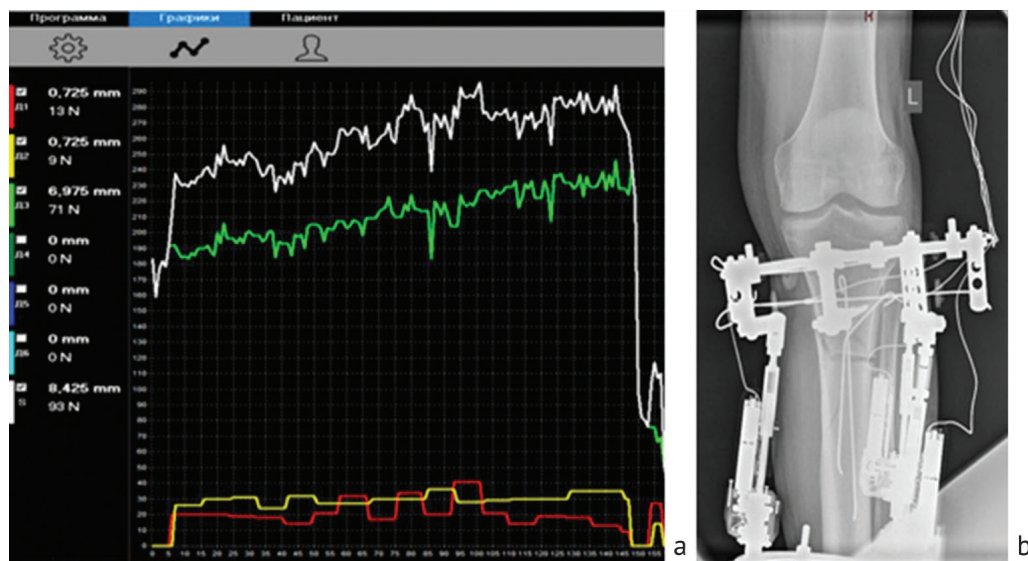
Dynamics of distraction forces with a sharp drop in the resistance level (a); control radiograph of the left tibia on the day of the disruptive event in the distraction forces (b)
